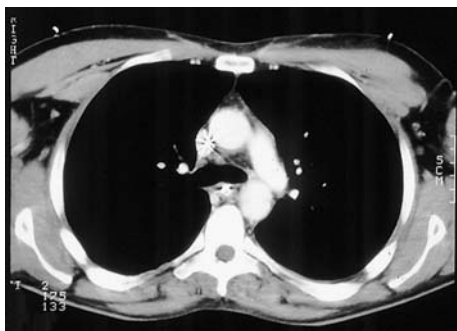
CT scan of a traumatic aortic rupture. An intimal tear is clearly visualized within the lumen of the isthmic aorta. No pleural effusion or periaortic hematoma is visible.
